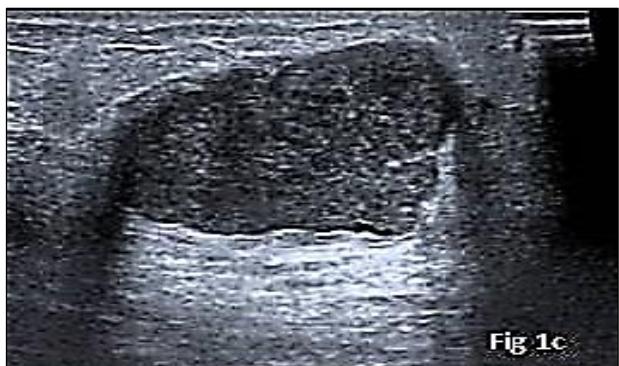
Ultrasound showing irregular not circumscribed micro lobulated hypoechoic lesion with significant posterior enhancement.
